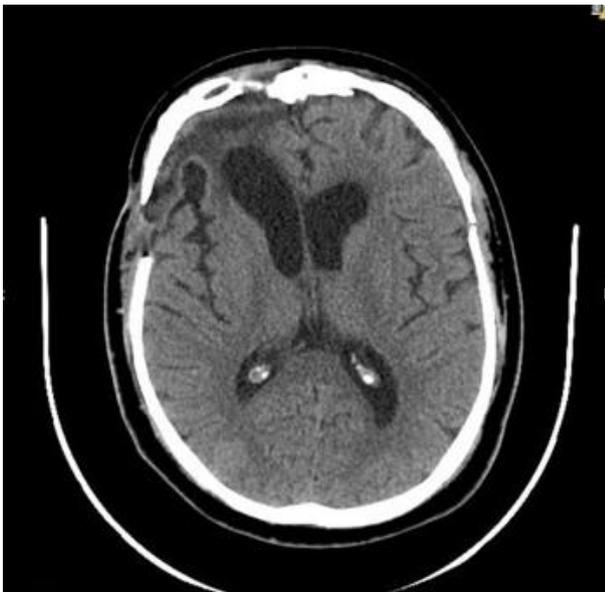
A Postoperative CT scan of the brain showing total excision of the tumor with regression of brain edema.
